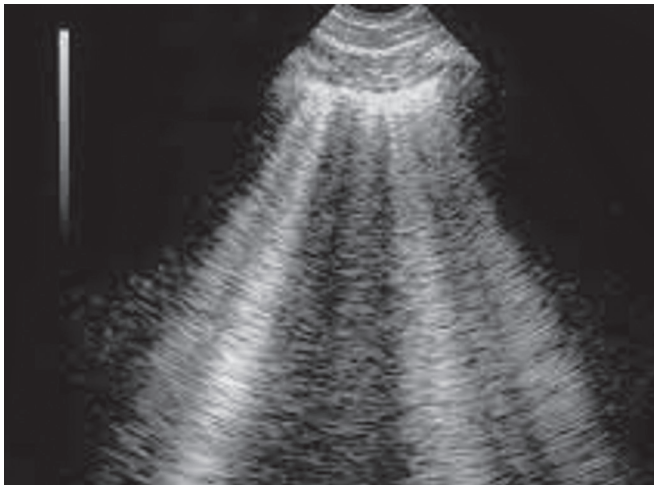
Ultrasound (USG) with B-lines
